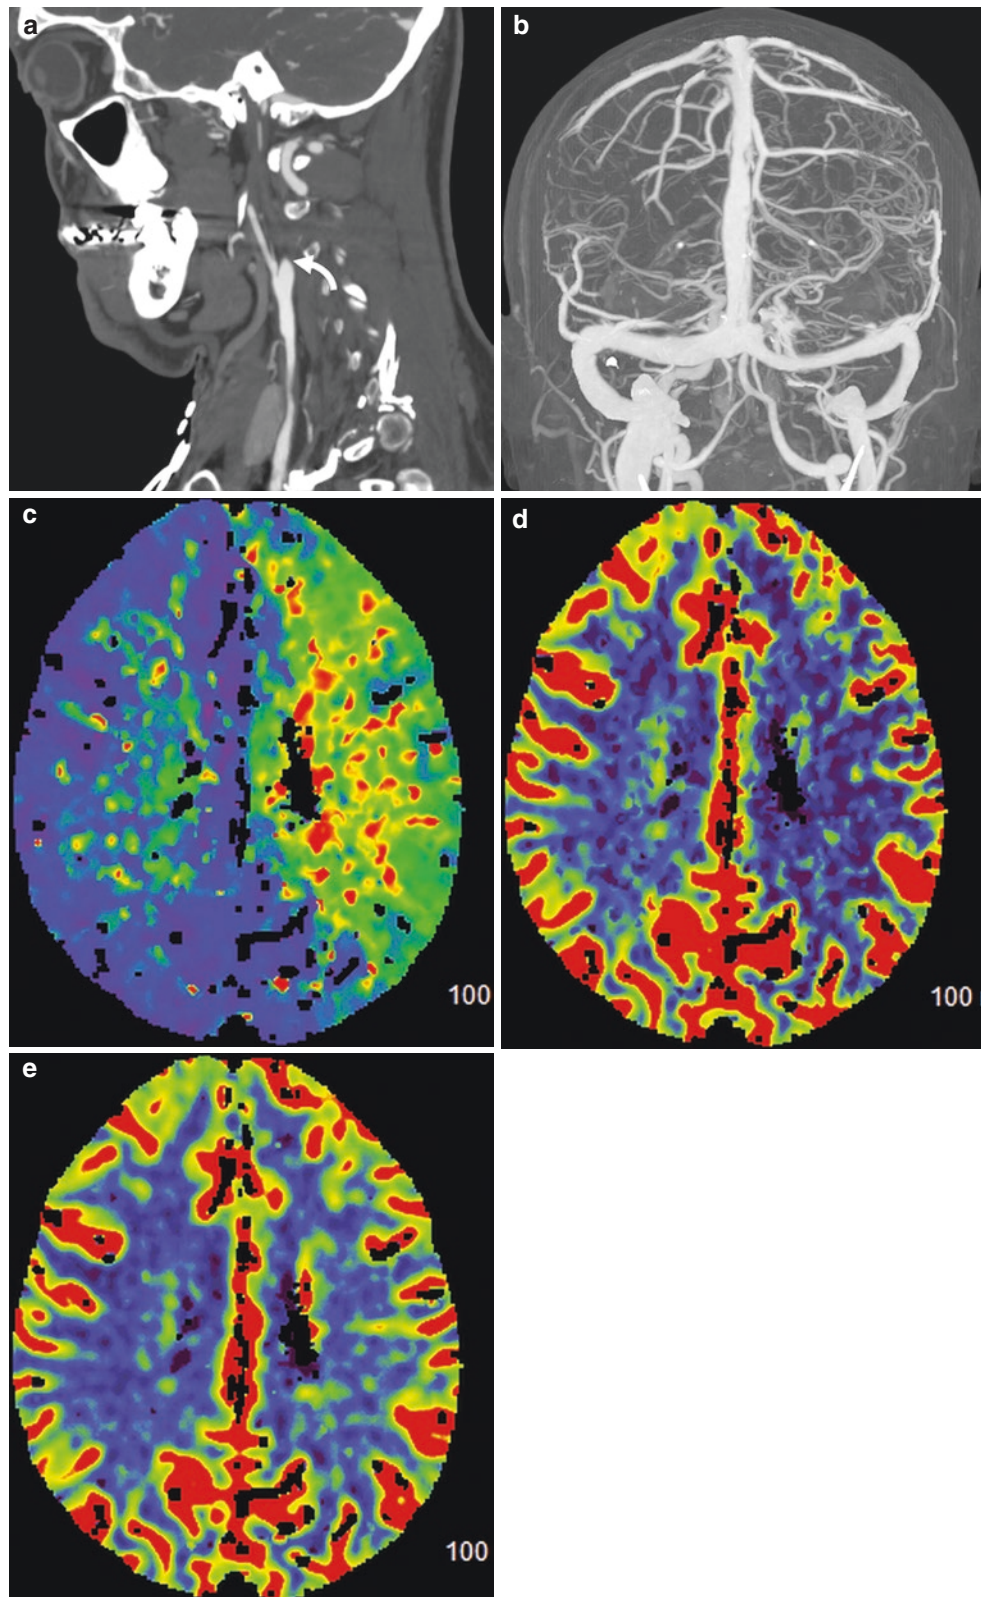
Pattern of compensated oligemia. Young patient with recent minor injury to the neck presents with transient right-sided weakness. (a), CTA neck demonstrates tapered occlusion of left cervical ICA consistent with a dissection (*curved arrow*). (b), 3D reconstructed image of head CTA shows reconstitution of left MCA with increased vascularity
